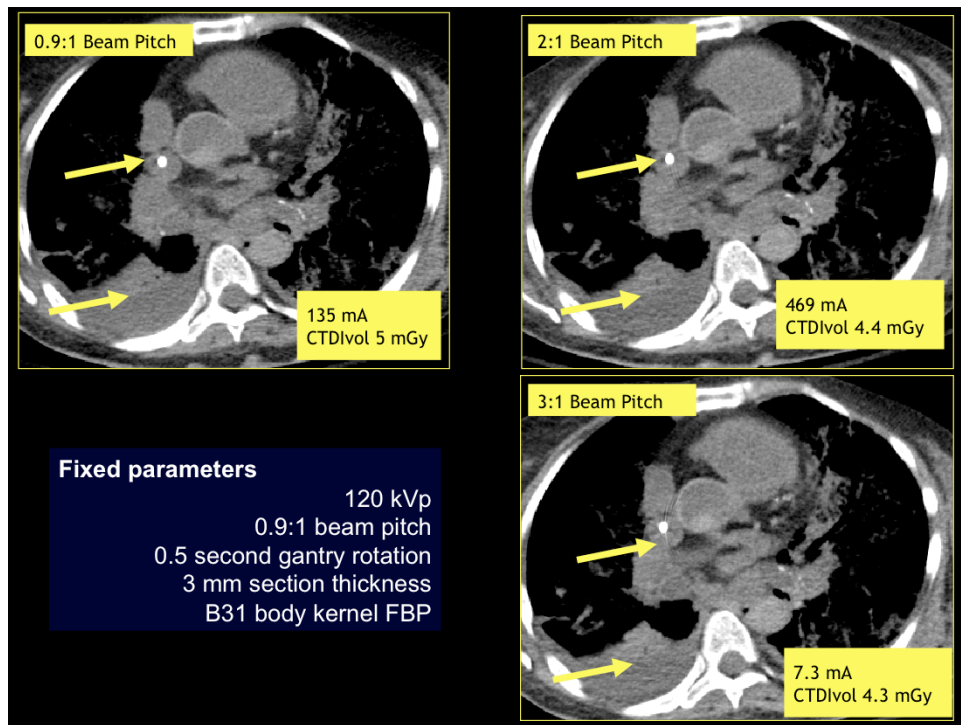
Postmortem chest CT at different beam pitches in a 60 year old female (54 kg) with known diagnosis of uterine adenocarcinoma. Transverse chest CT images acquired at higher beam pitch results in higher image noise in the mediastinum and helical artifacts due to high catheter in SVC (arrow).
